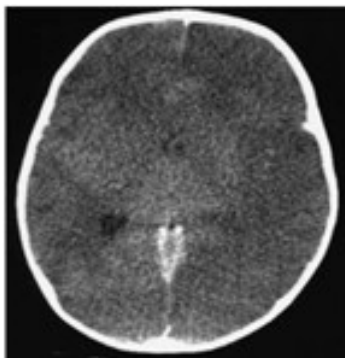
CT scan revealing generalized cerebral edema. Source: Figure by authors.
